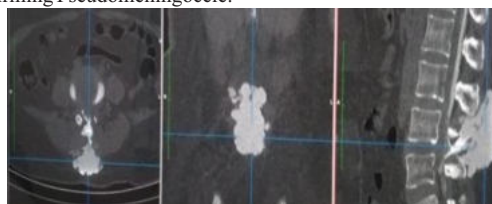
CT cisternography: G) Midline subcutaneous contrast opacified collection (3.6x 5.0 x 7.0 cm) at L4-L5 level (Post operative site) which is communicating with spinal subarachnoid space by dural defect of 5.5 x 4.5mm -Pseudo-meningocele.
